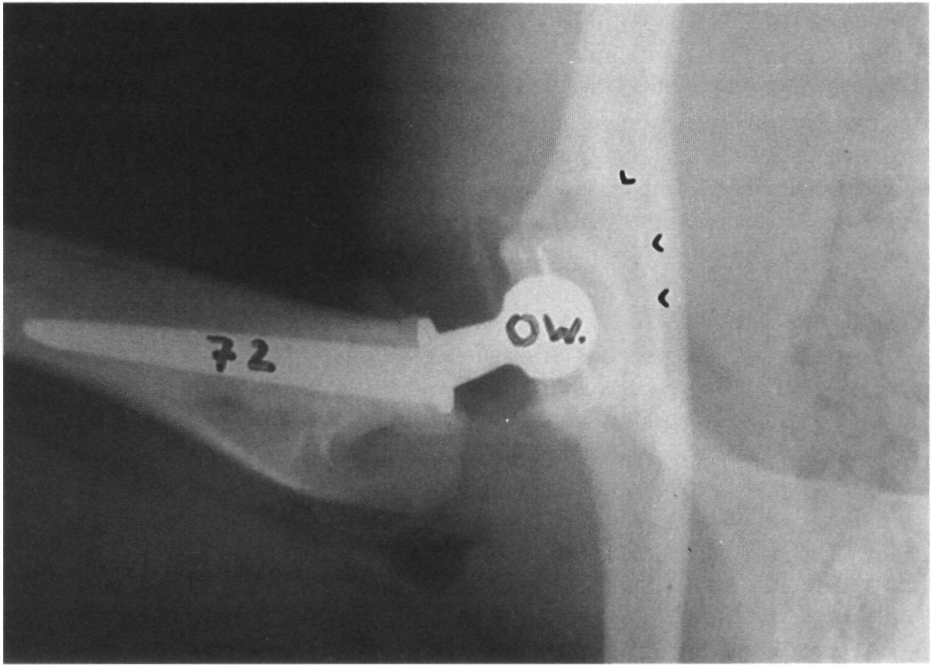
Antero-posterior radiograph of right hip in-vivo immediately after implantation. The grafted part of the acetabulum is clearly visible (arrowheads)
